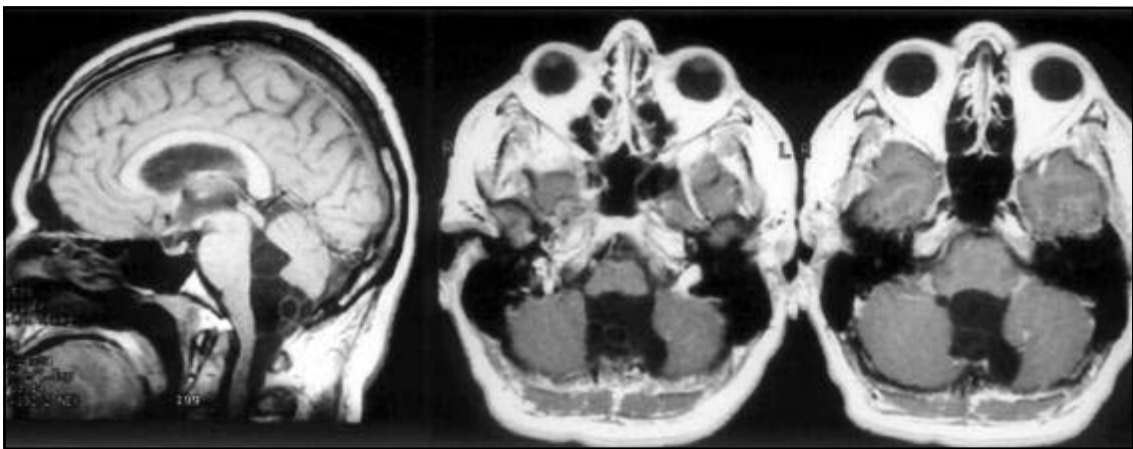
MRI Sagital T1WI and Axial T1WI postcontrast (Gd-DTPA): Racemous form in the cisterna magna with invagination into the IV ventricle.
